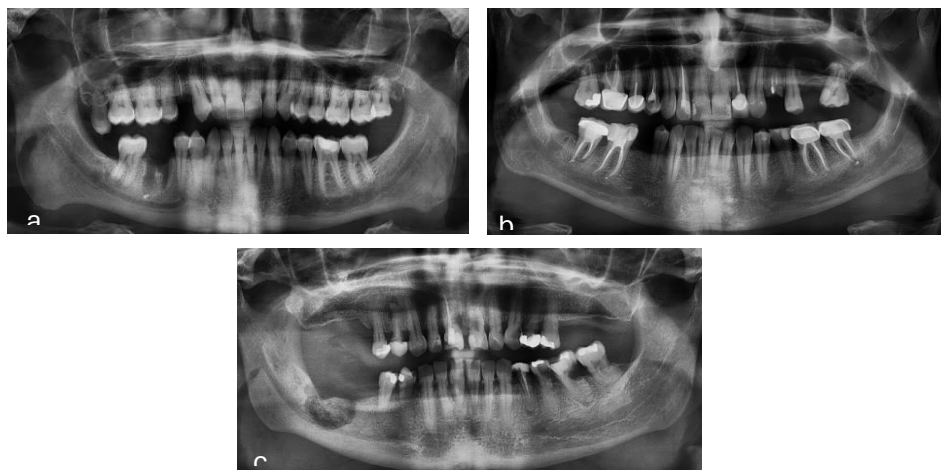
Panoramic radiograph of patient with normal healing (a), delayed healing (b), and MRONJ (c) in lower right mandible
